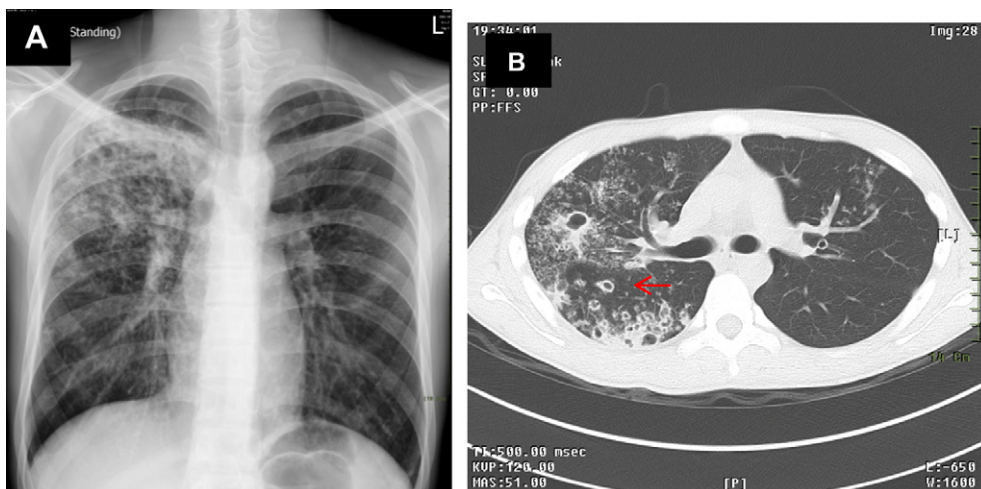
Secondary (post-primary) pulmonary tuberculosis. A 16-year-old male had a chronic cough and lost 10 kg bodyweight during the previous 6 months. (A) On admission, the chest X ray showed patchy, poorly defined consolidation with multiple cavitations over right upper lobe and upper segment of right lower lobe (posterior–anterior view). (B) Computed tomography (CT) showed bronchiectasis with bronchial wall thickening and a so-called “signet ring sign” (arrow).
